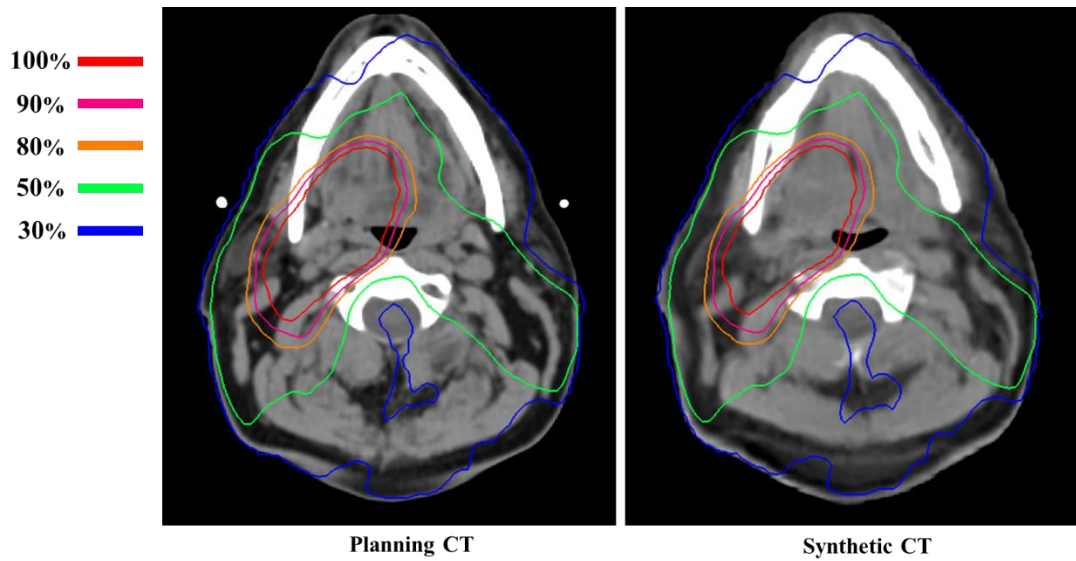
Dose comparison between planning CT and synthetic CT for a same treatment planning. The isodose lines are shown for comparison.
